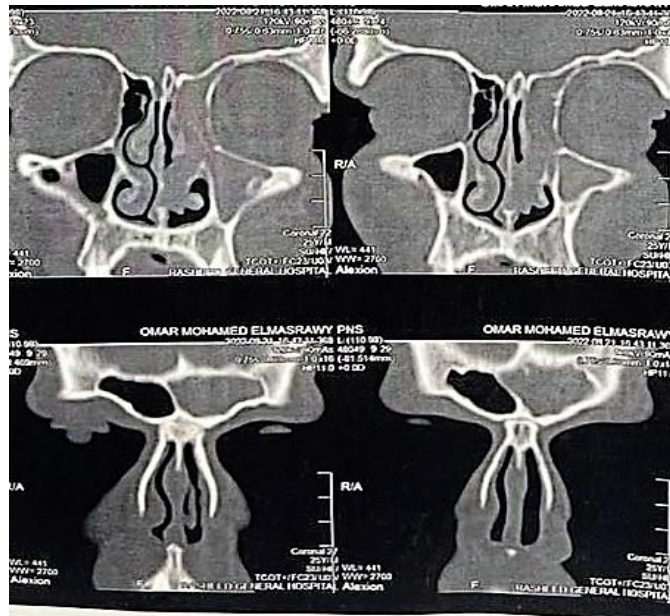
Preoperative CT scan (coronal cuts) showing isolated frontal sinusitis
